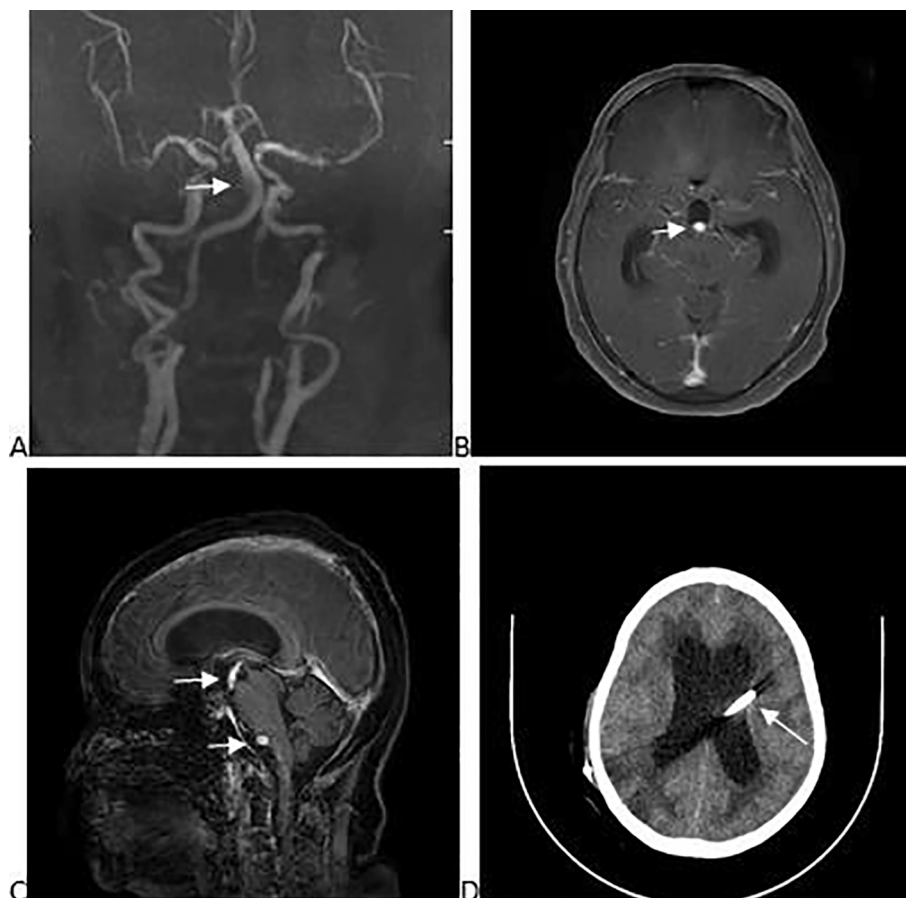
Magnetic resonance angiogram showing dolichoectatic basilar artery (Panel A) shown by white arrow. MR Contrast axial images depicting basilar artery in the floor of third ventricle shown with white arrow in panel B and in sagittal images (panel C). Panel D showing post-operative plain CT image showing ventriculo-peritoneal shunt in the lateral ventricle (white arrow).
